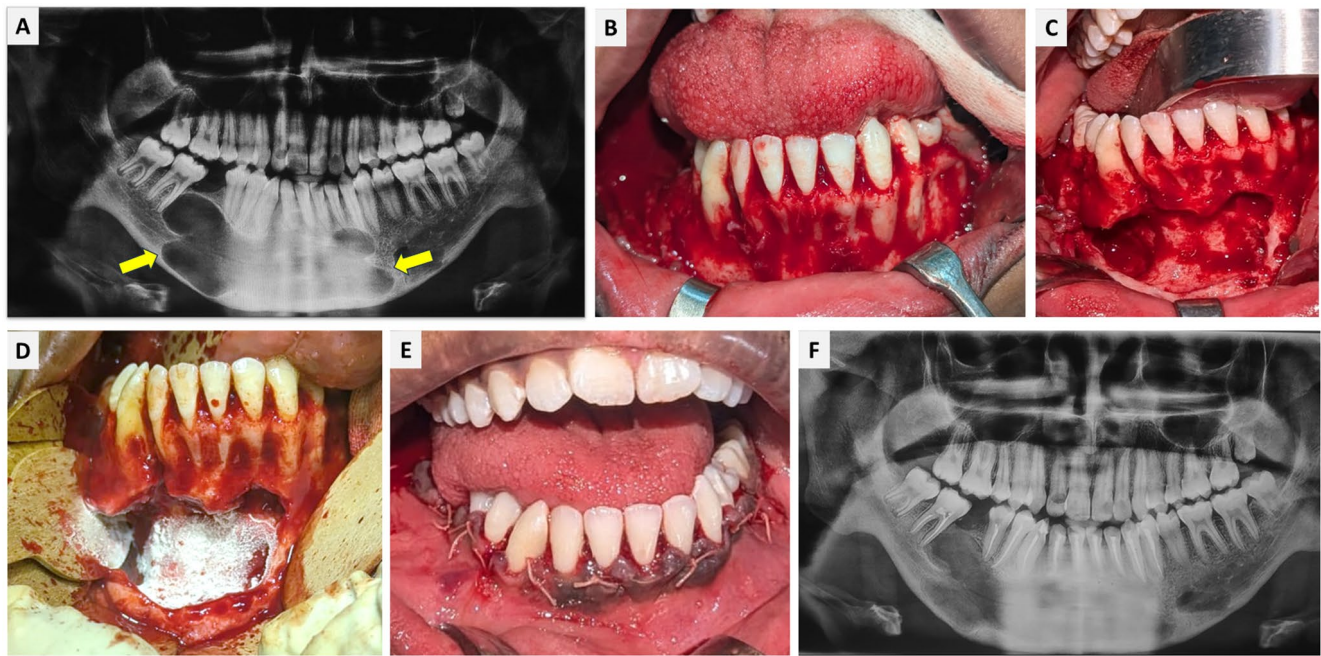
A Orthopantomogram showing odontogenic keratocyst indicated by arrows; B Incision and flap reflection; C Surgical cavity after cyst enucleation; D Liquid Nitrogen applied to the cystic cavity; E
